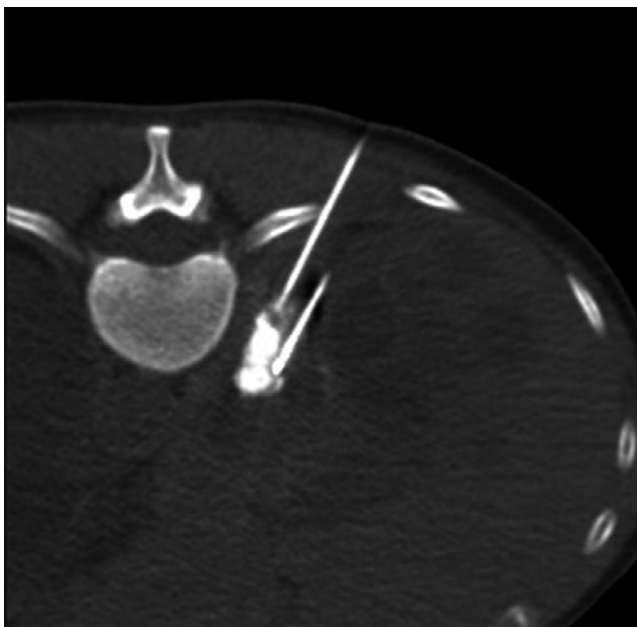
CT fluoroscopy axial image during RFA. Adrenal radiofrequency ablation was performed immediately after adrenal arterial embolization. Iodized oil is seen to have accumulated in the adrenal gland tumor. RF ablation is performed using two RF electrodes
